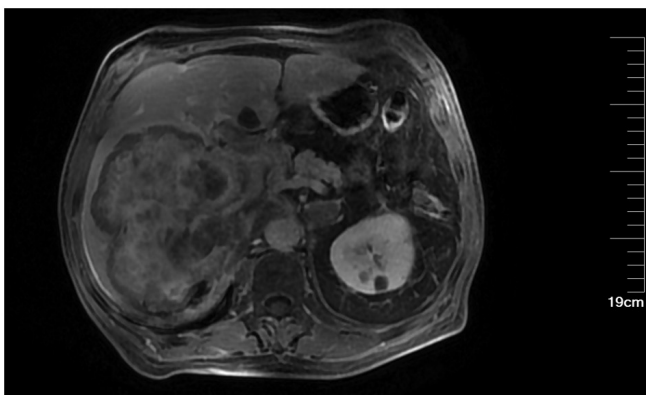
Case 1: Enhanced MRI of the liver. A massive mass along with multiple small nodules was observed within the right hepatic lobe, measuring ~13.7x12.6x11.4 cm.
